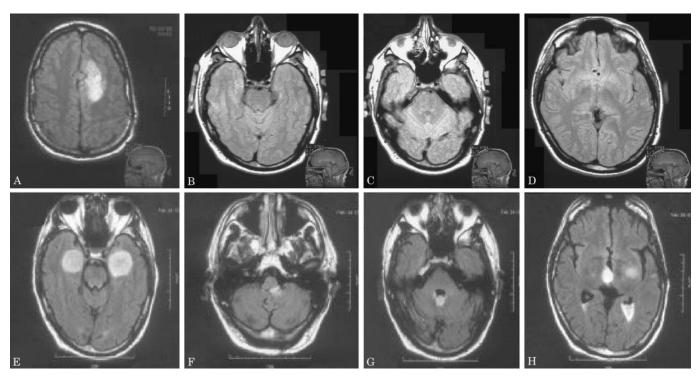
Axial FLAIR images. Post biopsy imaging of left cingulate gyrus lesion (A). Normal imaging at the time of biopsy of left cingulate gyrus lesion (B–D). Progressive lesions involving bilateral amygdala (E) and imaging performed 5 months later showing tumor progression involving the medulla, 4th ventricle, and medial dorsal aspect of the thalamus (F–H).
